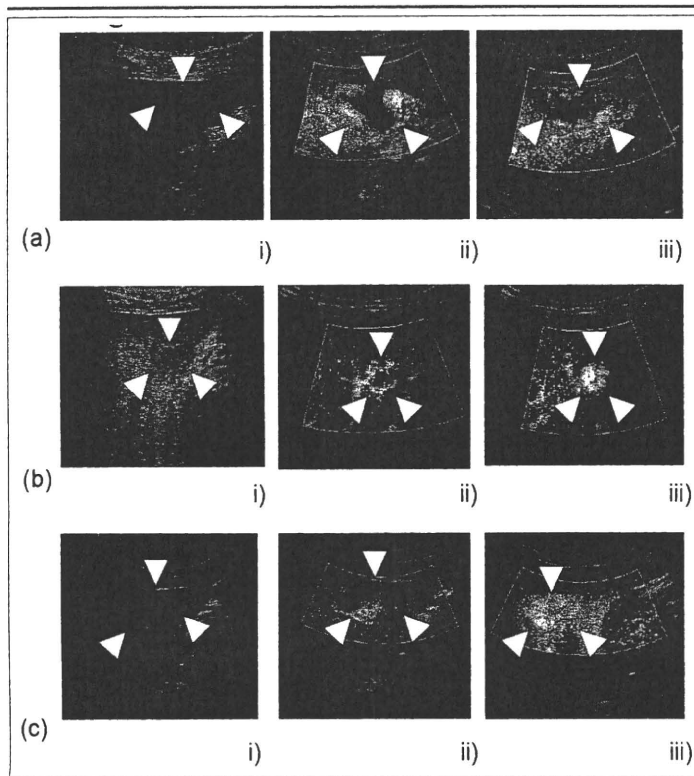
Time-related changes of contrast enhancement of hemangioma at the early-phase (a) Continuous type. i) Grayscale. Hypoechoic lesion was seen at segment III in the liver (39mm, arrowheads). ii) Contrast-enhanced sonogram of early-phase (40 s after injection). NE was observed in the lesion. iii) Contrast-enhanced sonogram of early-phase (50 s after injection). NE was observed in the lesion. (b) Transient type A. i) Grayscale. Hypoechoic lesion was seen at the segment V in the liver (19mm, arrowheads). ii) Contrast-enhanced sonogram of early-phase (31 s after injection). NE was observed in the lesion. iii) Contrast-enhanced sonogram of early-phase (37 s after injection) The lesion showed whole enhancement following NE, earlier than enhancement of surrounding liver parenchyma. (c) Transient type B. i) Grayscale. Hypoechoic lesion was seen at the segment III in the liver (40mm, arrowheads). ii) Contrast-enhanced sonogram of early-phase (30 s after injection). NE was observed in the lesion. iii) Contrast-enhanced sonogram of early-phase (48 s after injection). The lesion showed whole enhancement following NE, similar to the progression of enhancement in surrounding liver parenchyma.
